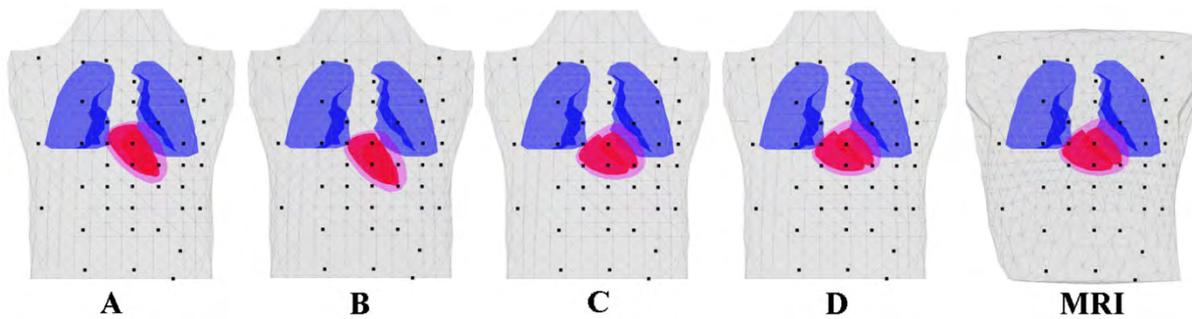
Example of 4 torso and heart models A, B, C, D used in the inverse computations (for torso P5 in Fig. 1). The fifth model (MRI) is the reference realistic MRI-based model used also in the forward computations.
